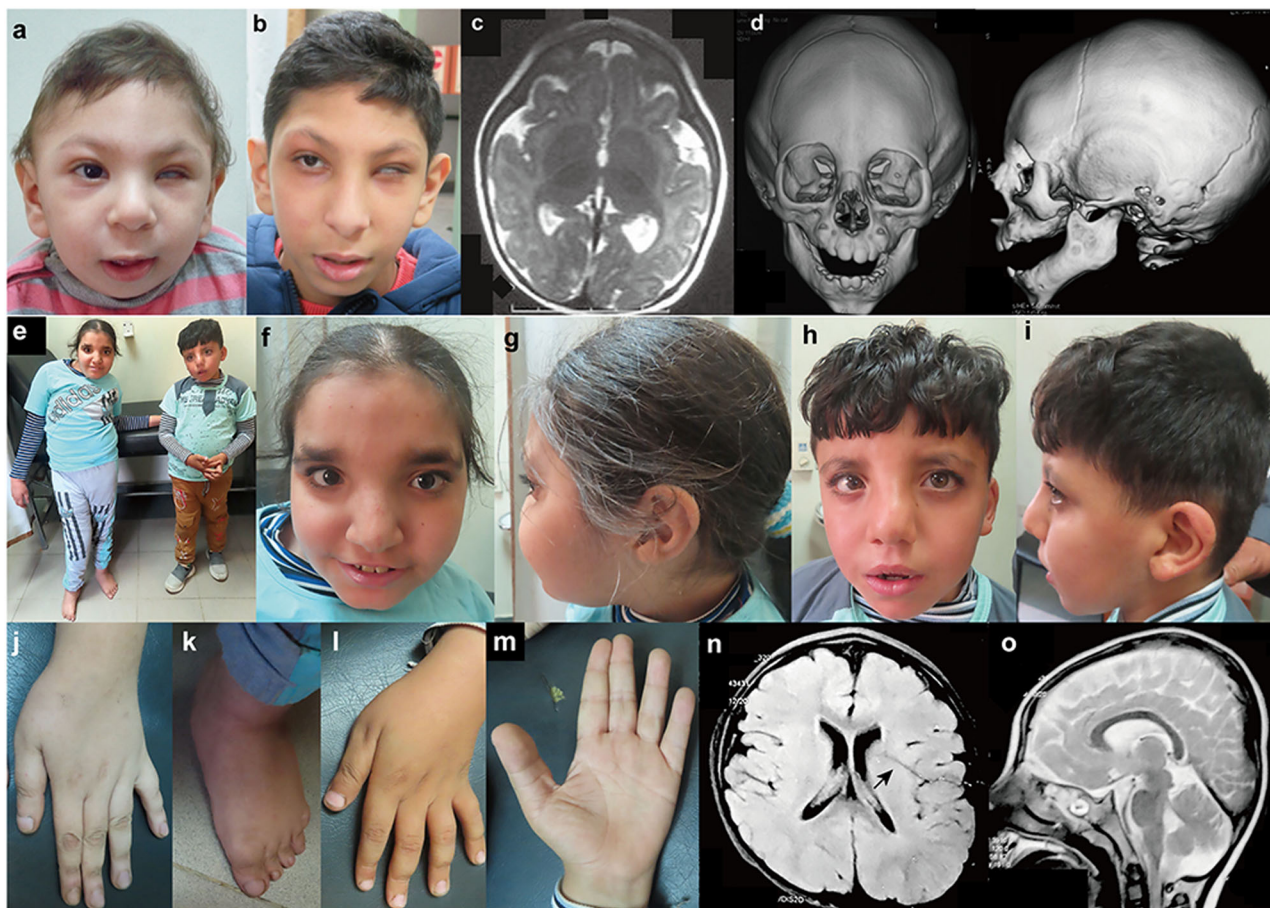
Clinical features of the patients homozygous for *GON4L* variants. Photographs of the face of Patient 1 at the age of 10 months (a) and 9 years and 6 months (b). He showed left microphthalmia. c Brain MRI of Patient 1 at the age of 5 months showed simplified gyral pattern. d Three-dimensional cranial CT images of Patient 1 at 10 months indicated metopic craniosynostosis. e Full picture of Patient 2 (left) and 3 (right). f, g Front and side of the face of Patient 2 at the age of 13 years old. She showed asymmetric face, a high forehead, thick eyebrows, upward slanting palpebral fissures, strabismus, broad nasal root, a broad nose with a beaked tip, deviated nasal
